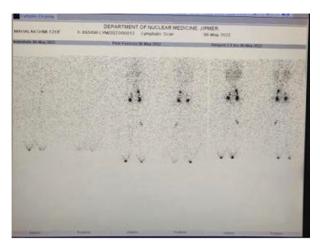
Lymposcintigraphy of both lower limb
